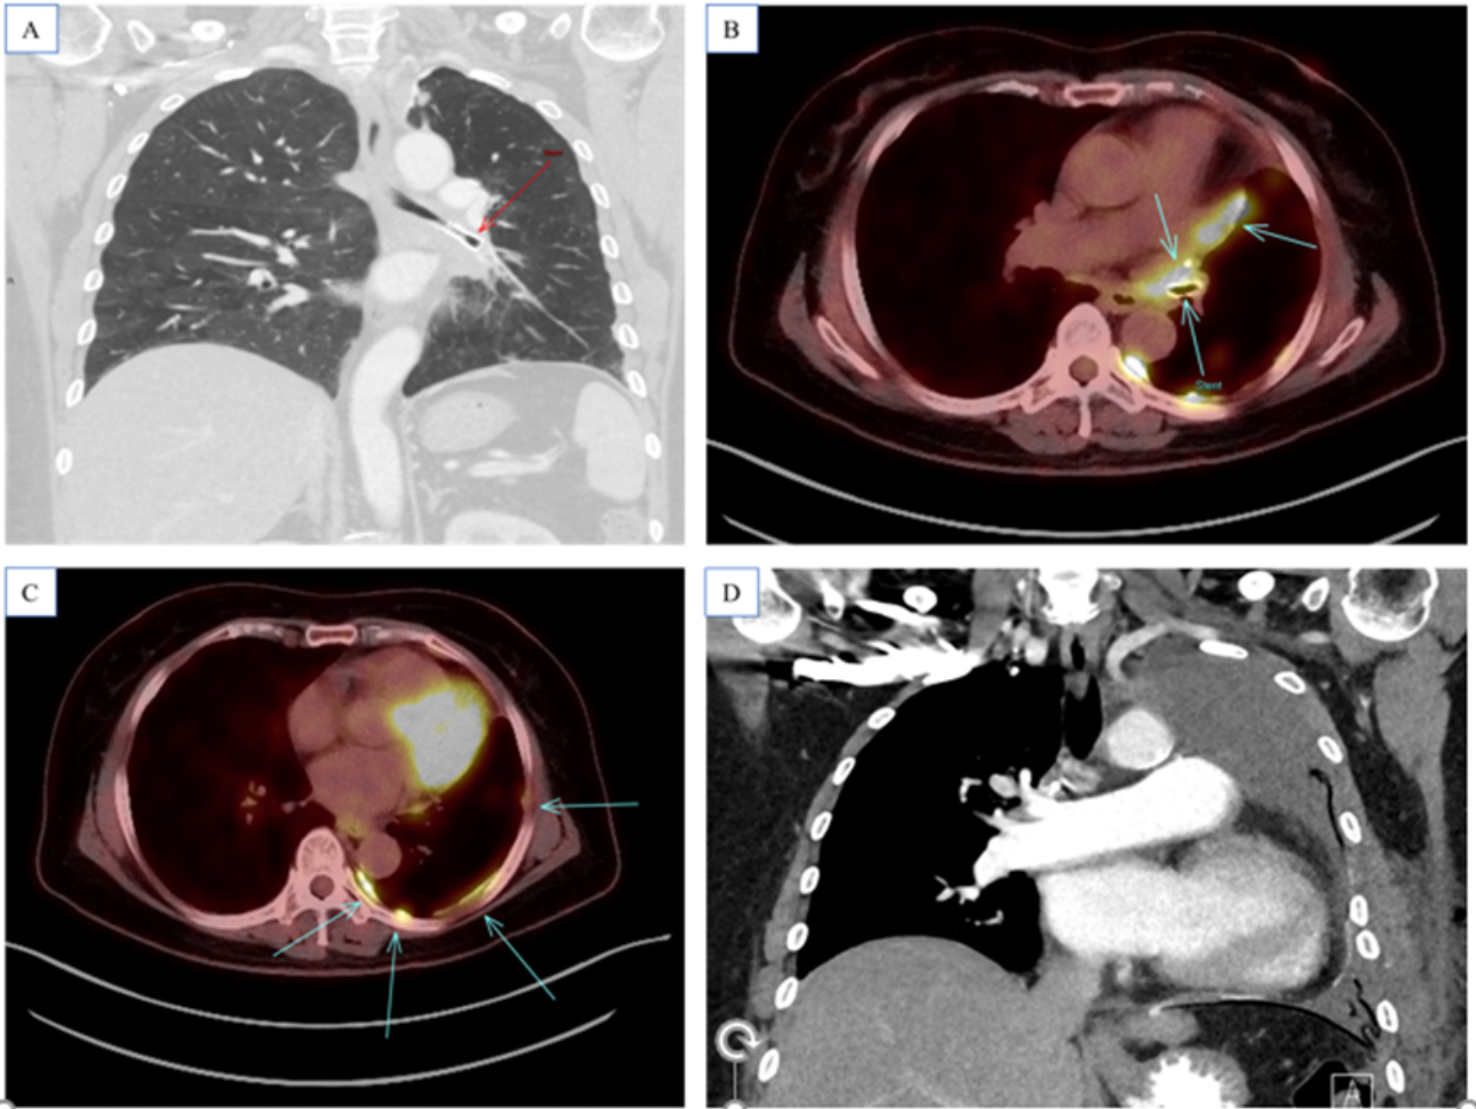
(A) Chest CT (status post left upper lobectomy) shows left lower lobe main bronchus obstruction with stent placement. (B) PET scan shows stent within left main bronchus with pleural and lymph node involvement by the tumor. (C) PET scan shows progressive involvement of left lower lobe and pleura by the tumor. (D) Chest CT status post completion extra pleural pneumonectomy.
